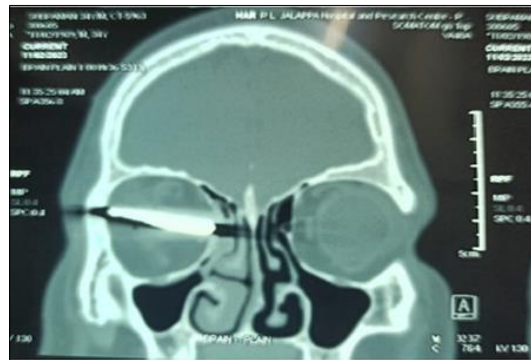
CT skull coronal section shows metallic foreign body lodged in right eye ball
